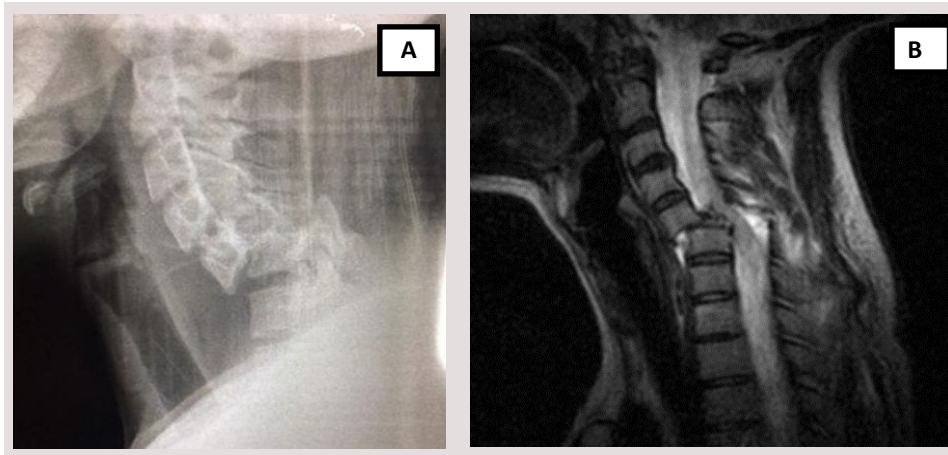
Preoperative imaging of unstable C5-C6 dislocation: (A) X-ray (B) MRI showing snapped cord.
